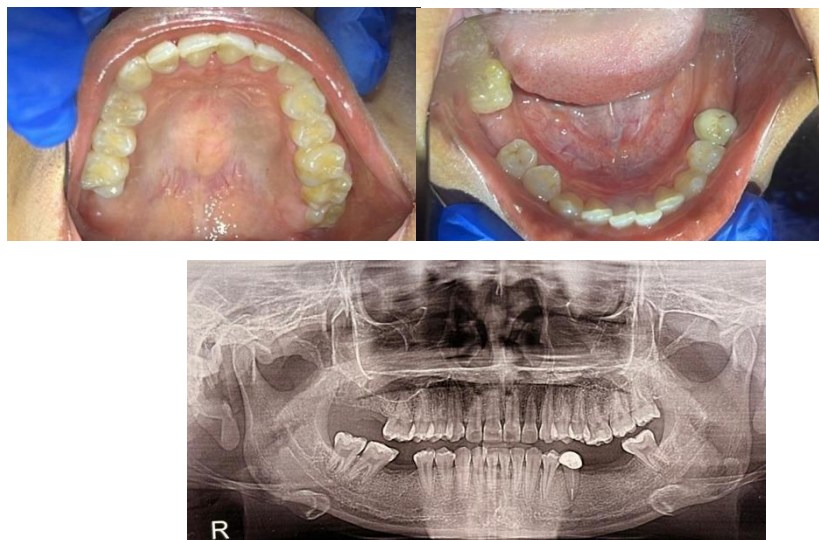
Panoramic Radiology
